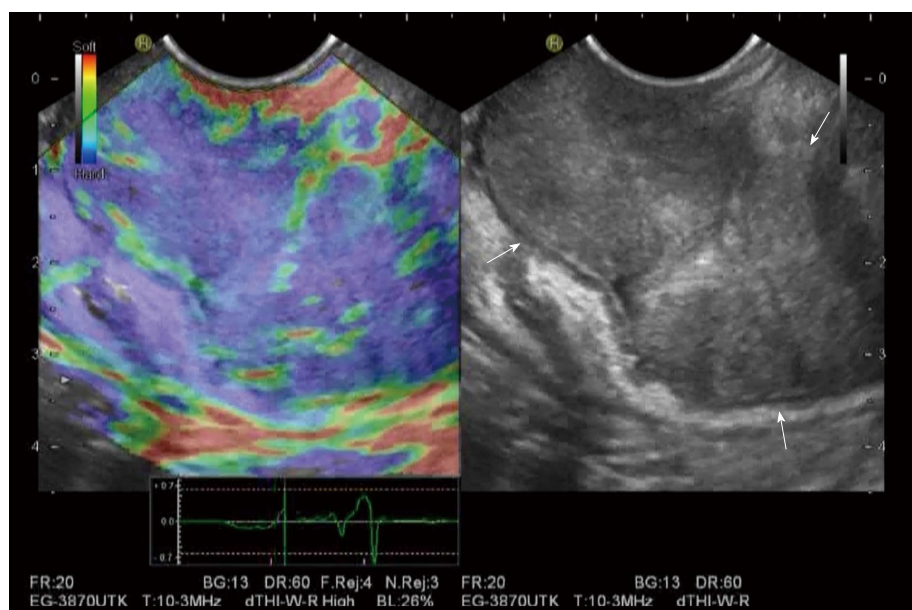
Gastric carcinoma is shown as heterogeneously stiff pattern (blue) on endoscopic ultrasound elastography.
